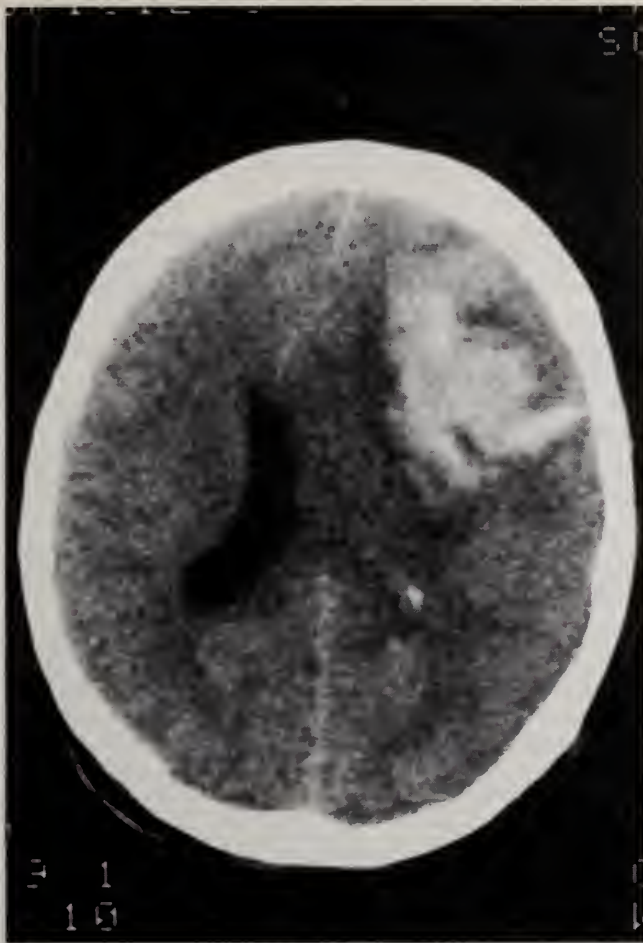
An axial CT section shows a hematoma in the left frontal lobe which is compressing the left lateral ventricle and displacing the midline from left to right.
